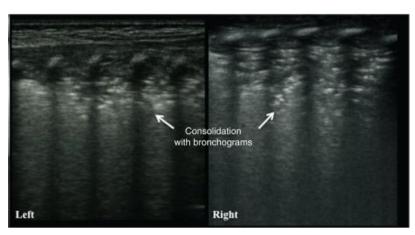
Ultrasound appearance of RDS
